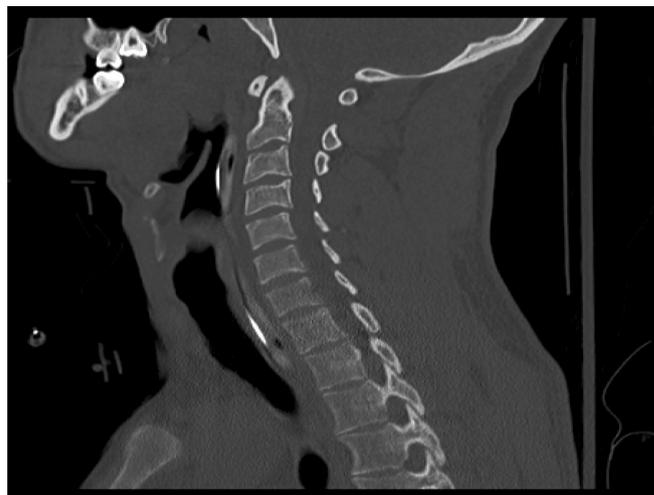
CT sagittal view of C-spine in patient with missed C-spine injury.
